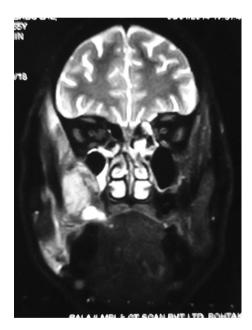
Preoperative MRI Coronal image showing a well defined mass on right side between medial and lateral pterygoid muscles (along the course of mandibular nerve) which is hyperintense
